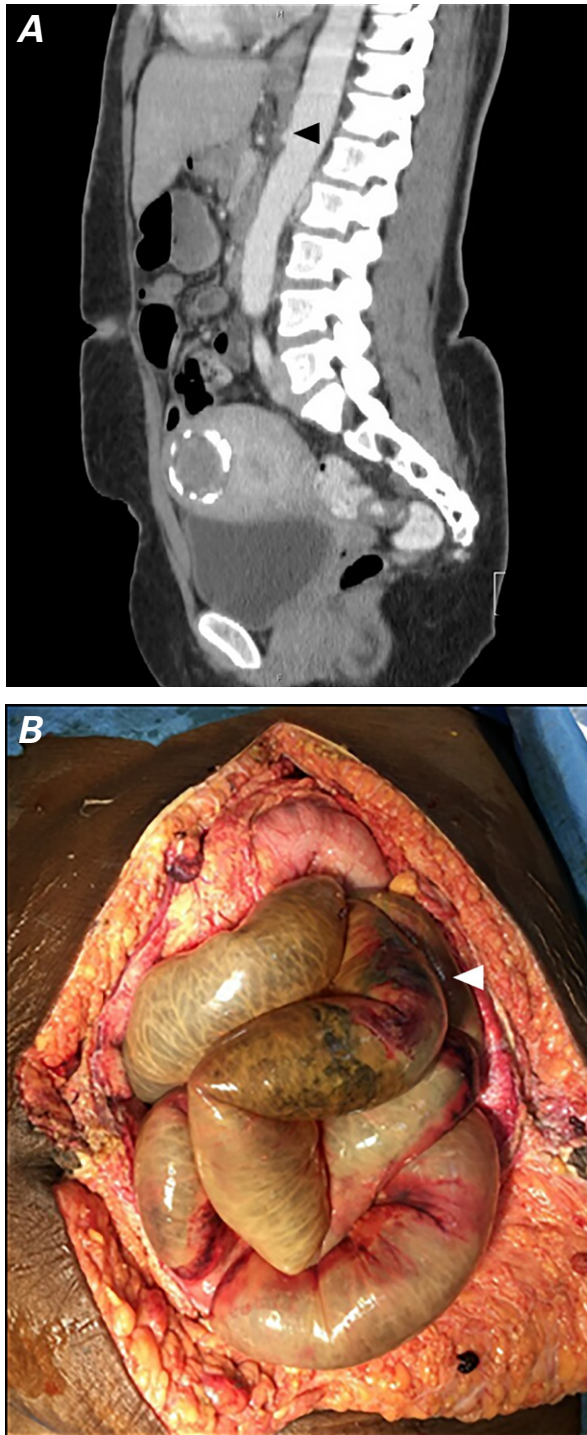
Patient 2. A) Computed tomographic angiogram (sagittal view) shows the occluded celiomesenteric trunk (arrowhead). B) Intraoperative photograph shows the infarcted small bowel (arrowhead).
